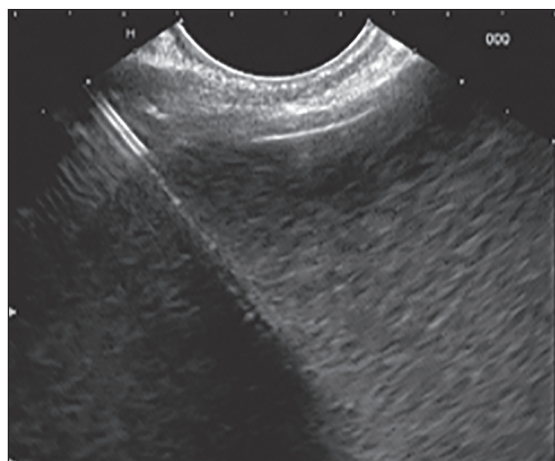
Naso cystic drain being placed in the cavity under endoscopic ultrasound guidance
